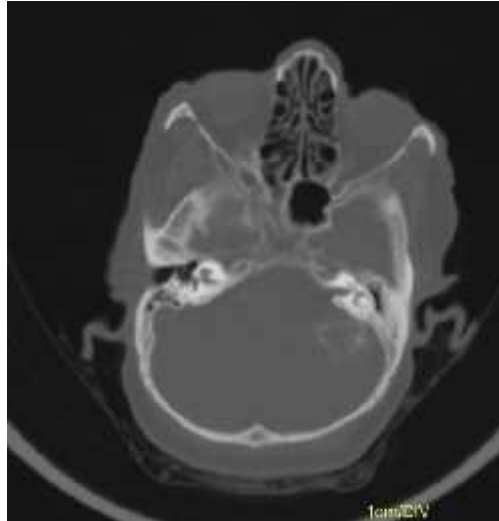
HRCT Axial bone window shows evidence of mass lesion near left cerebellopontine angle with few calcific foci within.
